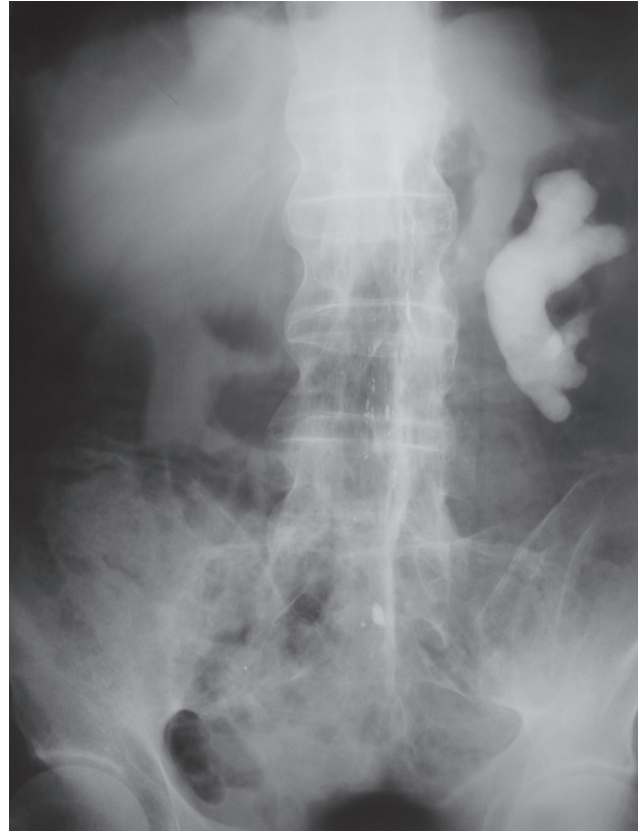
Left staghorn renal calculus in the plain radiograph.
